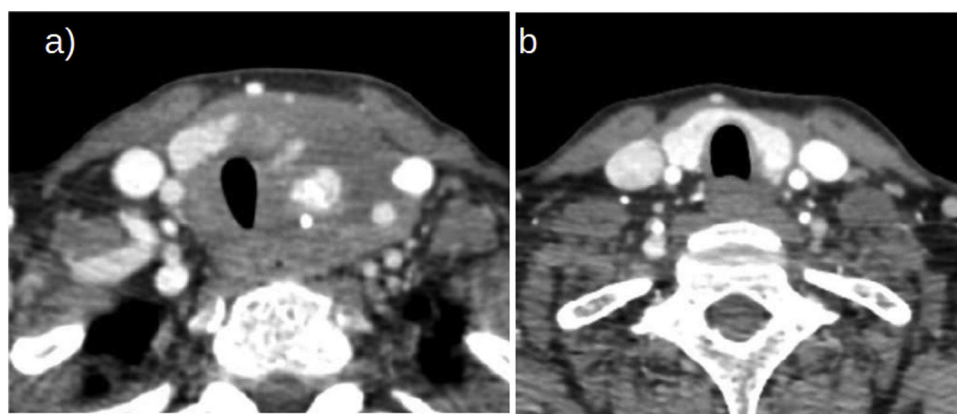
CT scan images at diagnosis of Riedel's thyroiditis (a) and at six months of corticosteroid therapy (b).
